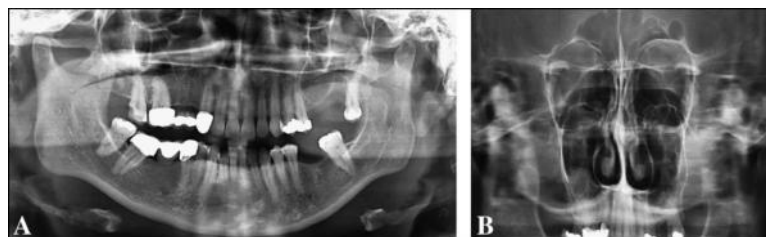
A, Panoramic radiography shows the absence of pathoses at the site of the previously glued OAC; B, the coronal view of the left maxillary sinus shows the absence of any pathoses, whereas significant pathoses are still present in the right untreated maxillary sinus.
